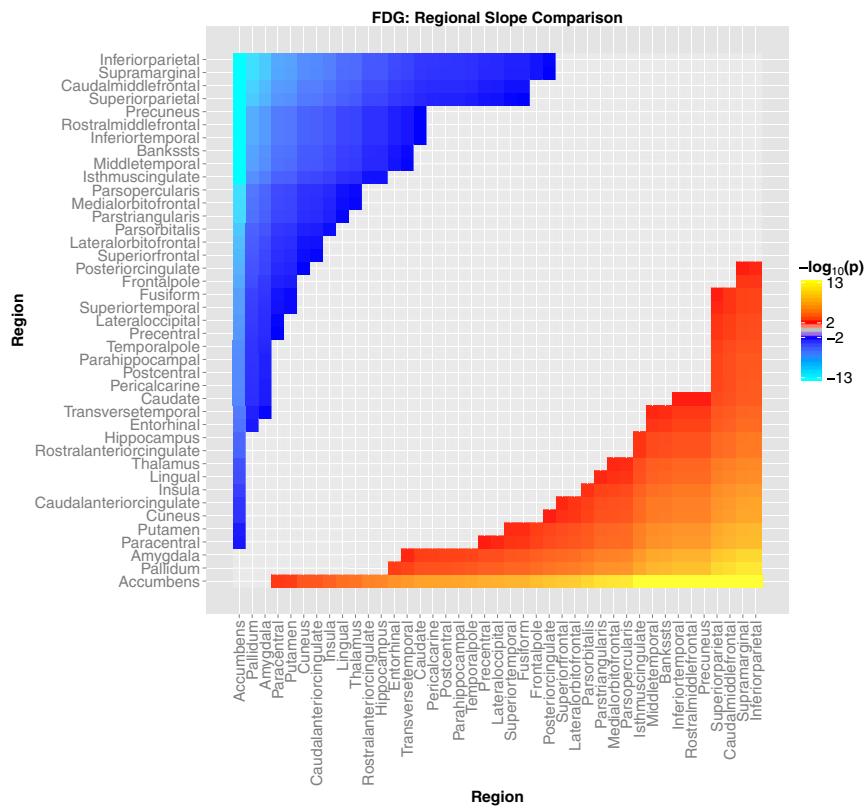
Comparison of the cross-sectional slopes for each FDG region in mutation carriers. Conventions as in Fig. S1.
